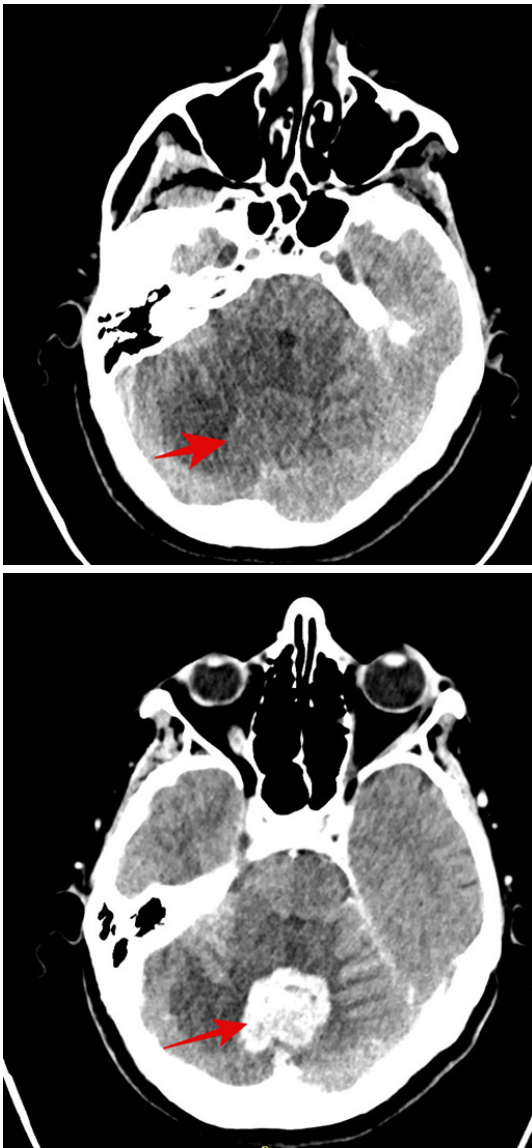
(A) Non-contrast CT (25/04/2024) scan (B) contrast CT (8/05/2024), shows a pathological lesion in the cerebellum.
